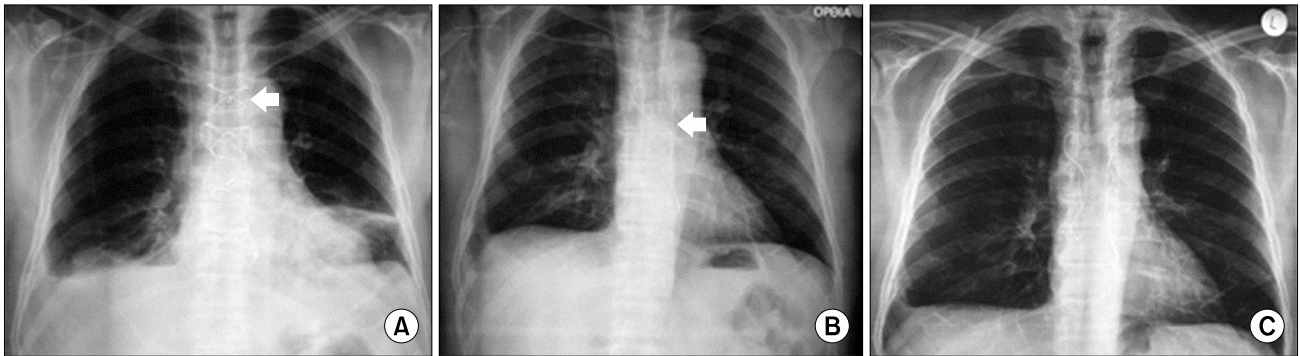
Chest X-ray evolution. (A) Bilateral Robicsek and figure-eight sternal closure during initial surgery (arrow). (B) Sternum appearance after debridement with parasternal wires retained *in situ* (arrow). (C) Chest X-ray of the patient 5 years after debridement.
